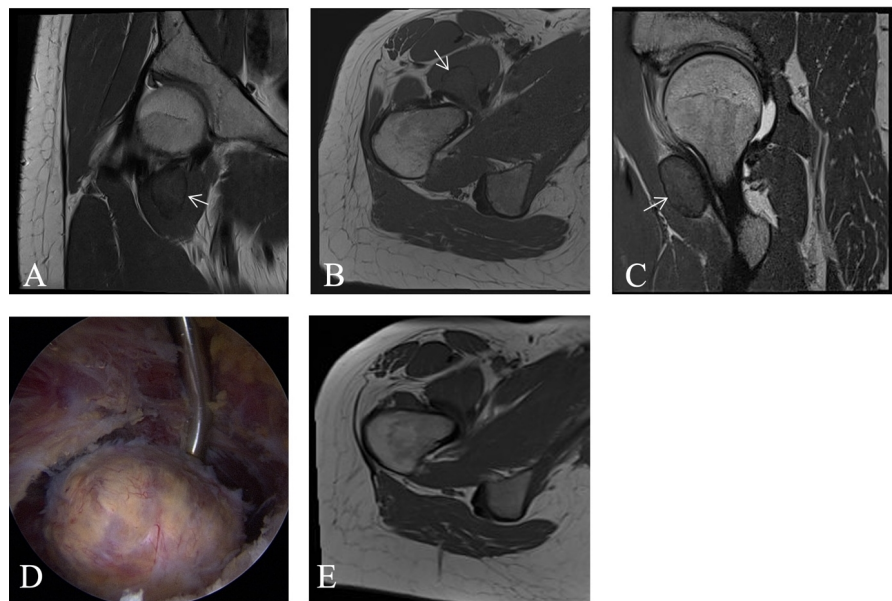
Preoperative MRI of the right hip in coronar (A), transversal (B) and sagittal (C) plane. Arrow marking the TGCT in (A)-(C). D: Arthroscopic view into the psoas compartment imaging the dissected tumor. E: Postoperative MRI of the right hip in transversal plane showing no tumor recurrence 3 years after surgery.
